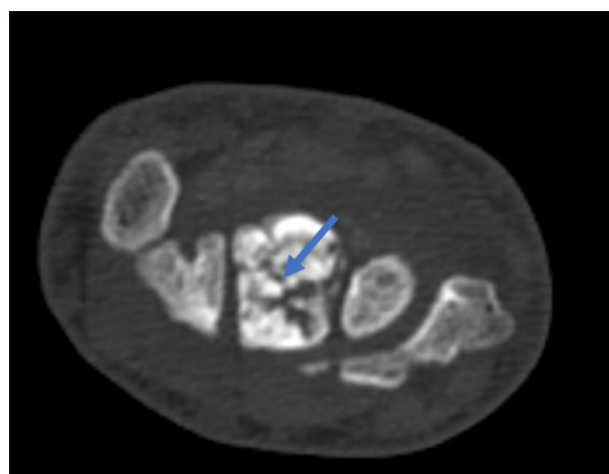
Axial CT image of the wrist showing a dense and fragmented lunate (blue arrow)
